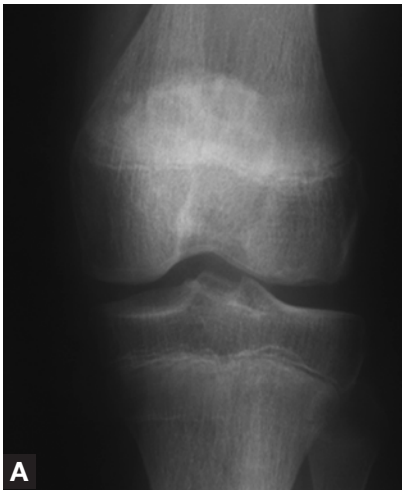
Case 1—Anteroposterior (A) and lateral (B) x-rays 16 months after injury show healed patella and femur fractures with no evidence of angular deformity or asymmetric physeal closure of the distal femur.
